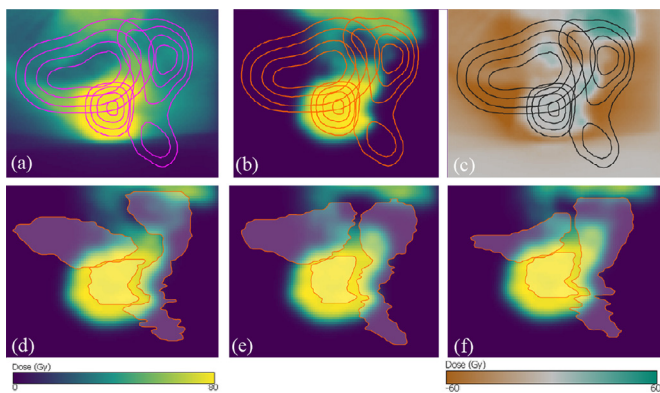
Comparison of treatment plans for a single patient, shown on the sagittal view: (a) Photon plan. (b) Proton plan. (c) Difference between (a) and (b). (d–f) Anatomical changes occurring over treatment. Organ contours from CT acquired (d) prior to treatment, (e) in the first, and (f) in the second treatment week.
